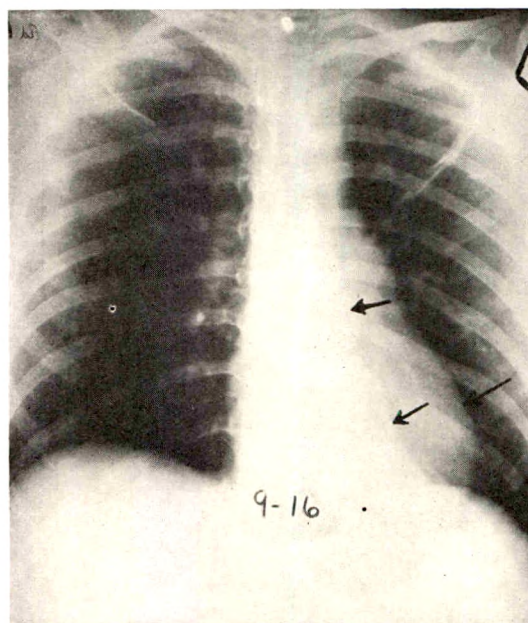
Roentgenogram of Case v taken two days after Figure 8. Shows a spontaneous decrease in the size of the left-sided mediastinal pleural effusion. Arrows indicate the lateral border of the encapsulation. Compare with Figure 8.
